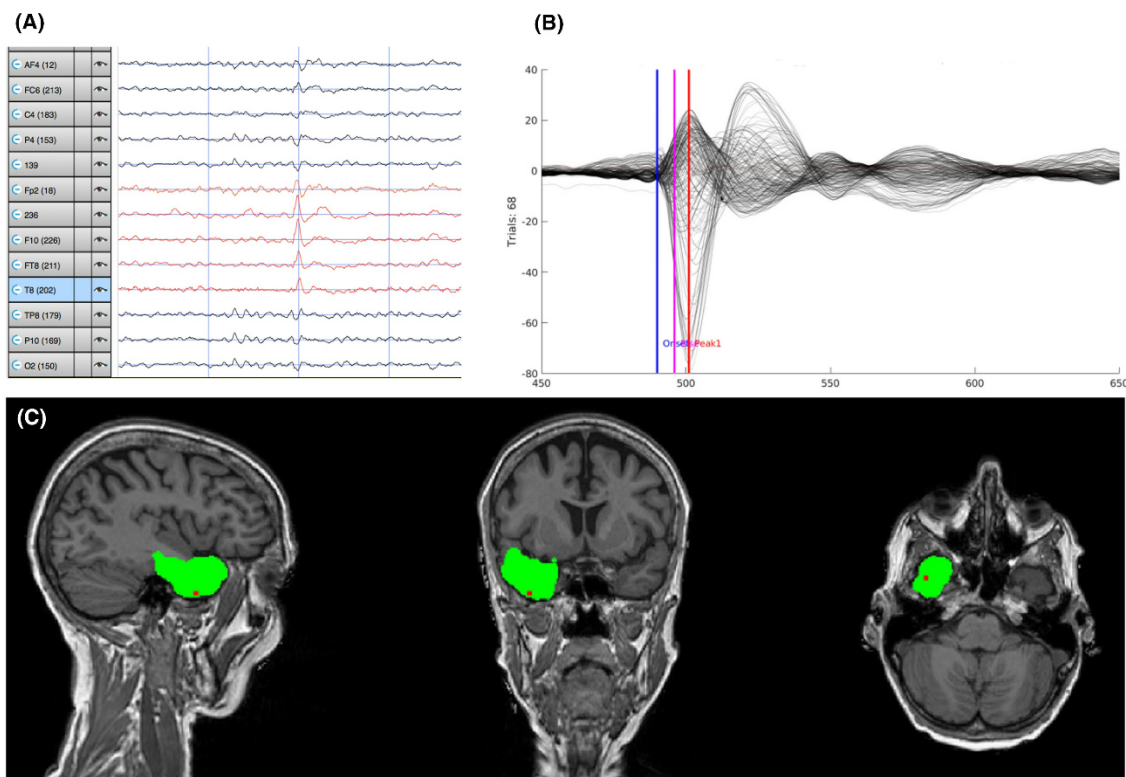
ESI results of an MRI positive patient with 256-channel hdEEG. The patient was Engel class 1A at 1-year follow-up after anterior temporal lobectomy. Pathology confirmed hippocampal sclerosis. Single IED on the right temporal electrodes displayed on an extended average montage (A). An average of 68 IEDs (B). HdESI with resected volume (green) and the maximum amplitude of ESI (red point) (C). wMNE sublobar localization was right temporal. Euclidean distance was 0 mm with source maximum being in the resection zone.
